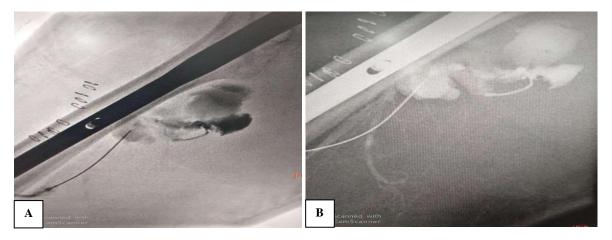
(A and B): Ultrasonogrphy guided embolisation at the pseudoaneurysmal site using thombin.
